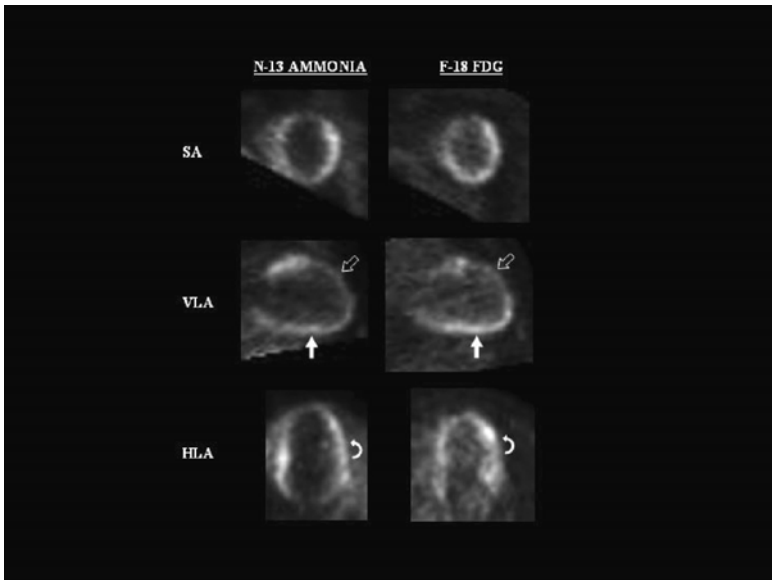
Myocardial viability study (^{13}N ammonia perfusion and ^{18}F FDG metabolism) of a 53-year-old man with coronary artery disease and ischemic cardiomyopathy being considered for coronary artery bypass graft surgery. There is a completed transmural infarct with non-viable myocardium (matched defect with severely diminished perfusion and FDG metabolism) in the anterior segment (open arrows) and segmental ischemic viable myocardium (mismatched defect with diminished perfusion, but preserved FDG metabolism) in the inferior segment (closed arrows). Normal viable myocardium (matched normal perfusion and FDG metabolism) is demonstrated in the lateral segment (curved arrows).
